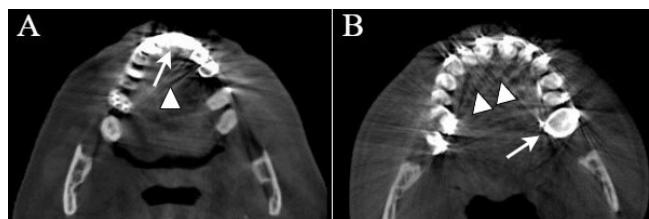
Axial CBCT images (A and B): Cupping artifact (white arrows) and dark band (arrowheads) are shown.
